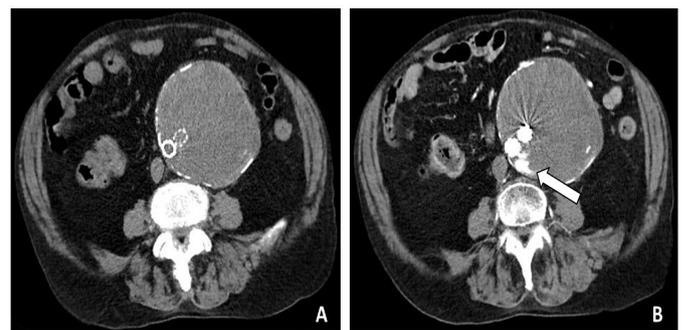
Preoperative plain and contrast-enhanced CT on type II endoleak after EVAR (case 12). (A) A plain CT image shows the high intensity prosthetic stent graft inside enlarged abdominal aortic aneurysm. (B) On contrast-enhanced CT, a contrast agent inflow outside of endoprosthesis lumen and within the aneurysm sac is seen developing from lumbar artery (arrow). CT, computed tomography; EVAR, endovascular aneurysm repair.
